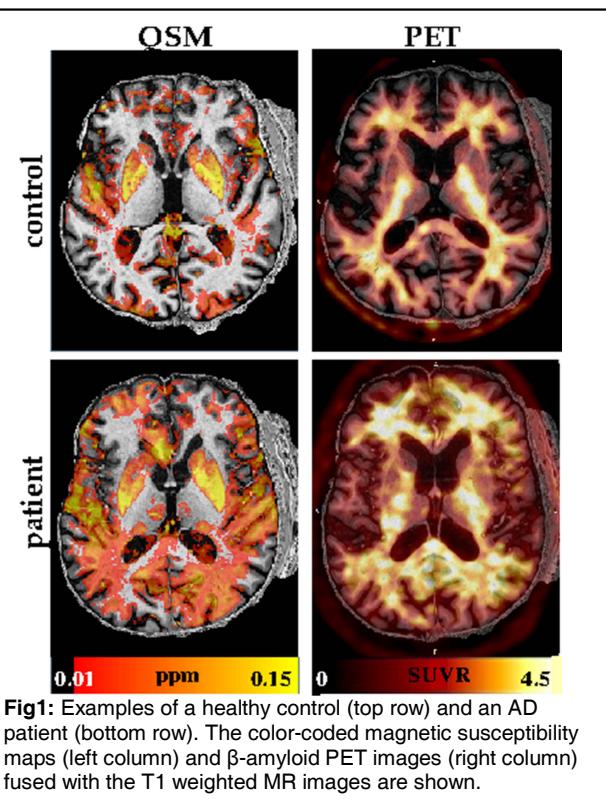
Examples of a healthy control (top row) and an AD patient (bottom row). The color-coded magnetic susceptibility maps (left column) and β -amyloid PET images (right column) fused with the T1 weighted MR images are shown.
